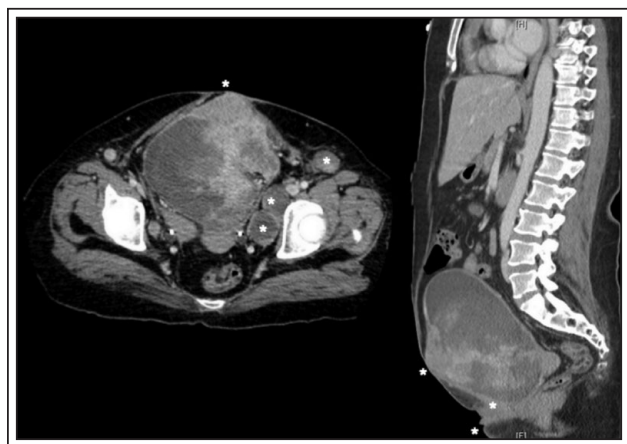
Contrast enhanced CT abdomen and pelvis. There is a large, heterogeneous, enhancing bladder mass extending into the abdominal wall, relative paucity of rectus musculature, absent symphysis pubis and large necrotic pelvic and inguinal lymphadenopathy (up to 3 cm).
